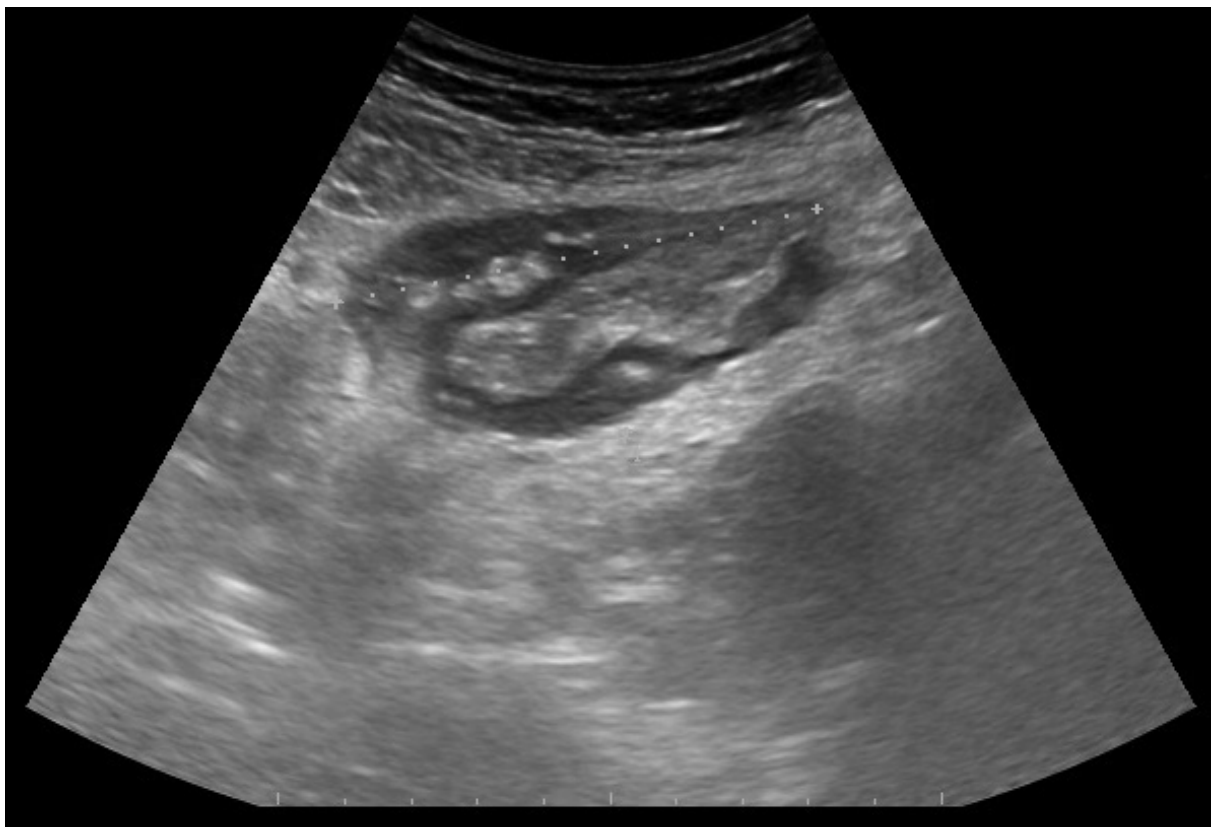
Ultrasound image of a pseudokidney lesion in the sigmoid colon
